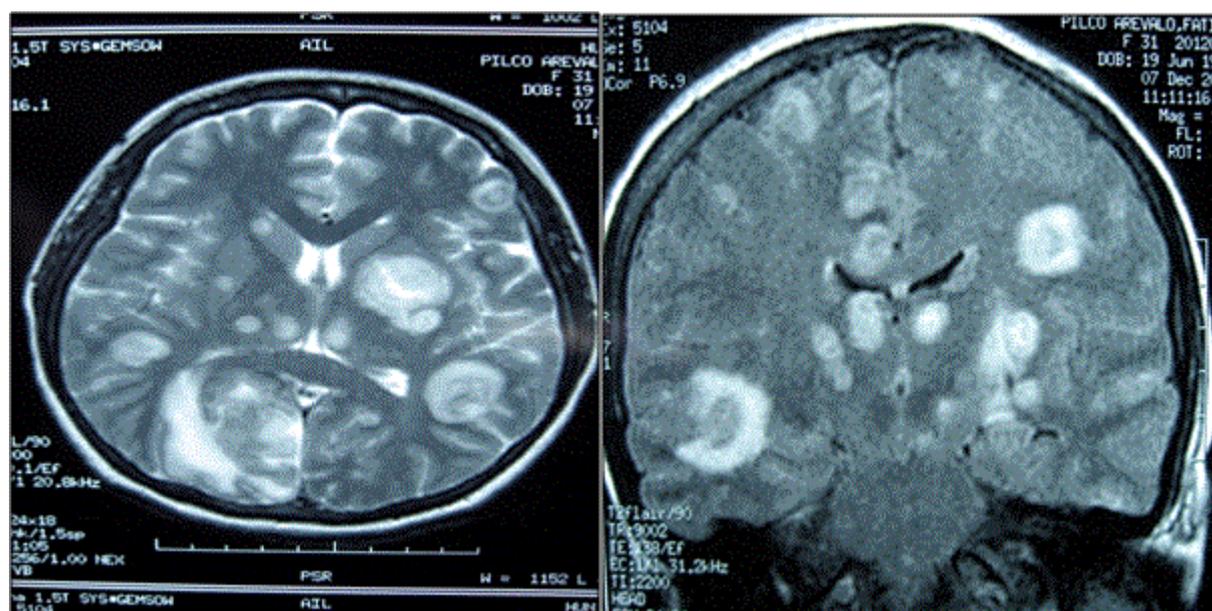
A and B CT and MRI brain images
